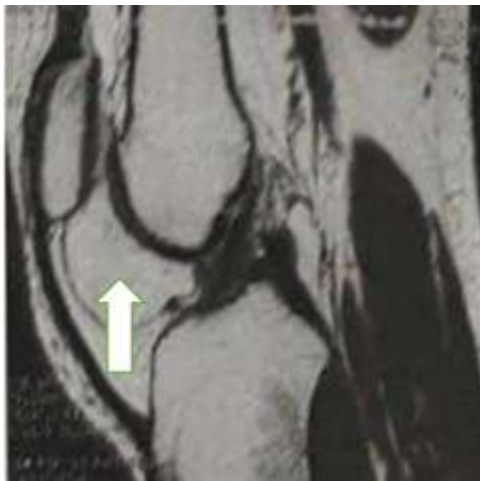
Sagittal T2 MRI depicting a well-encapsulated fat intensity lesion in Hoffa fat pad consistent with lipoma (arrow).
